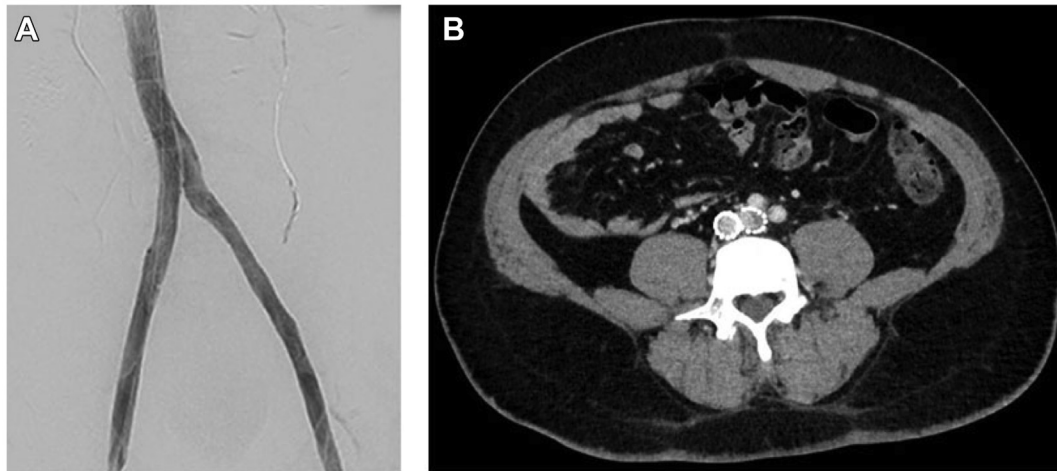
Iliocaval reconstruction completion venogram for index procedure (A). Follow-up computed tomography (CT) venogram with presence of left external iliac vein (EIV) stenosis (B).
